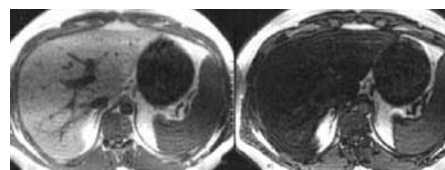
Diffuse hepatic steatosis is depicted by the homogeneous loss of signal between in-phase T1-weighted GRE (FLASH TR 160, TE 4.4, FA 80) image, left, and out-of-phase T1-weighted GRE (FLASH TR 160, TE 2.4, FA 80) image, right.
